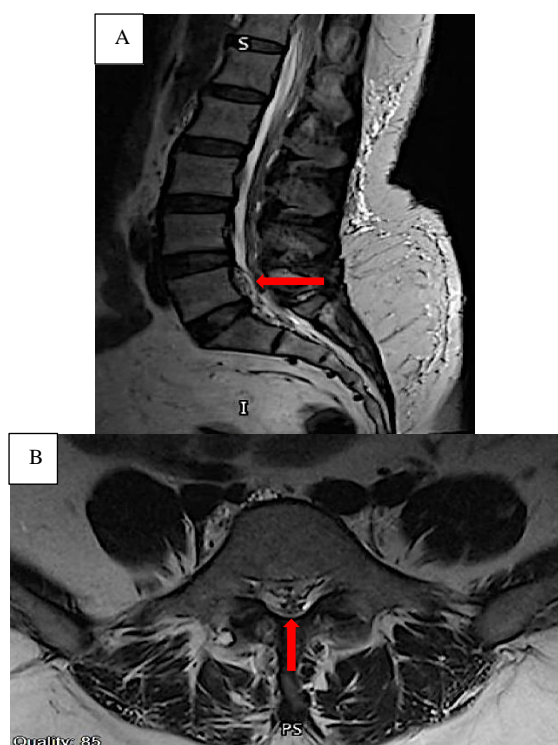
Sagittal (A) and axial (B) cuts of T2 weighted magnetic resonance imaging (MRI) of the lumbosacral spine showing an oval-shaped lesion (red arrow) at the posterior aspect of L5-S1, causing significant lumbar canal stenosis
